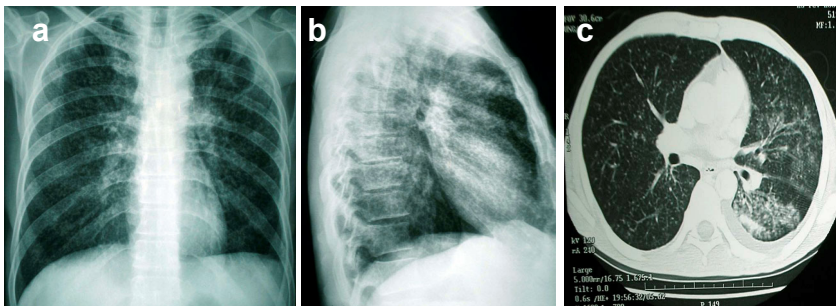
Miliary pattern of primary TB in adults. a and b: chest X-ray, c: computerized tomography.
